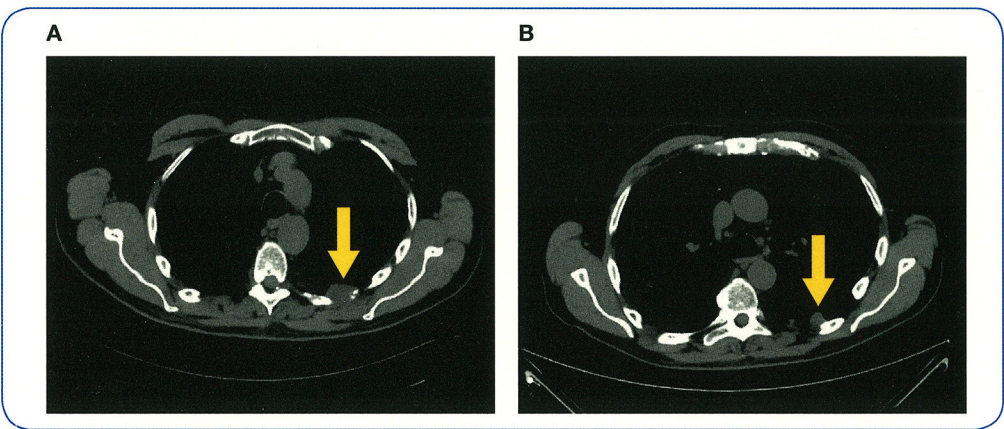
Computed tomography scans of patient 15 at baseline (panel A) and cycle 23 (panel B).
